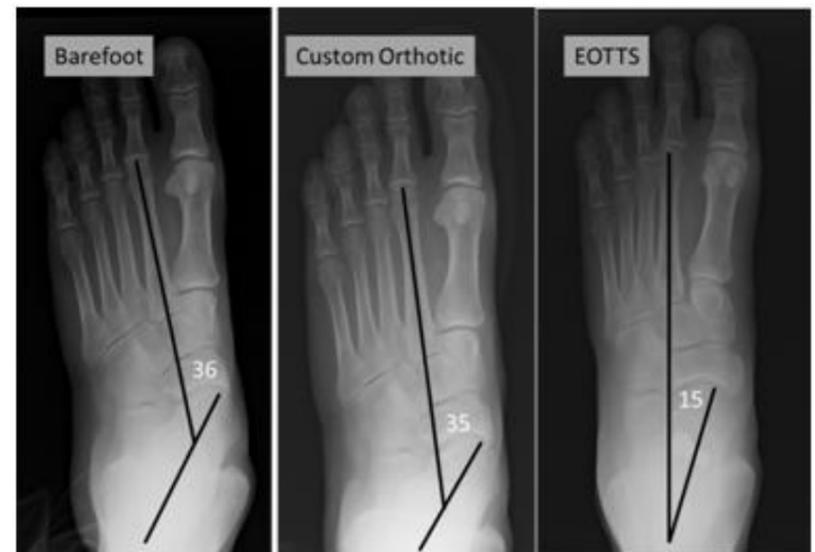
Sample weight-bearing anteroposterior radiographic angle measurement of the talar second metatarsal angle (a) barefoot/no intervention (b) with orthosis (c) after extra-osseous talotarsal stabilization (EOTTS).
